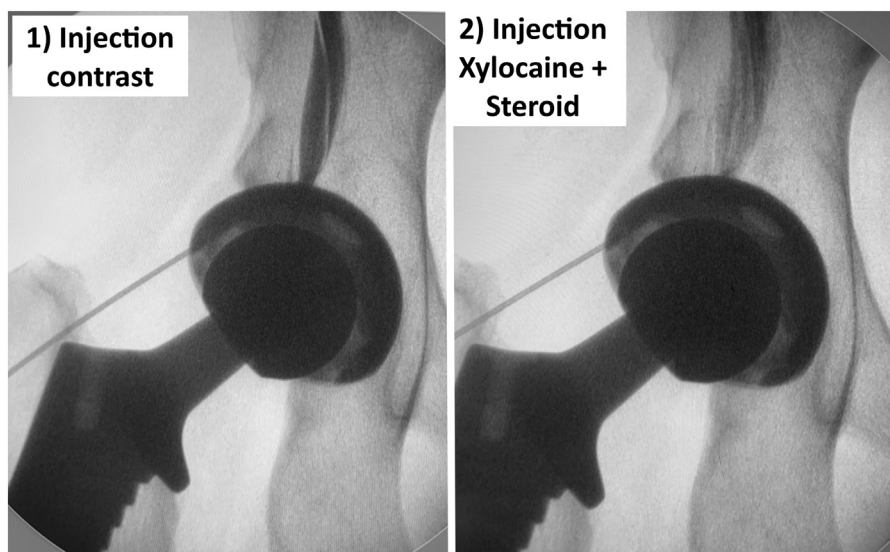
Fluoroscopy-guided psoas tendon sheath injection. The procedure is done under sterile circumstances in the operating room. With the patient-positioned supine, the fluoroscopy C-arm is positioned to take an anteroposterior X-ray of the hip. Step (1) The target zone was the center of the superior acetabular roof. A spinal needle was used and its position was verified using fluoroscopy. The needle was advanced until the tip of the needle reached the acetabular bone. Correct needle position was confirmed by longitudinal spread of a small amount of injected contrast agent. Step (2) Injection of 4 mL of Xylocaine and 1 mL of Depo-medrol 40 mg/mL.
